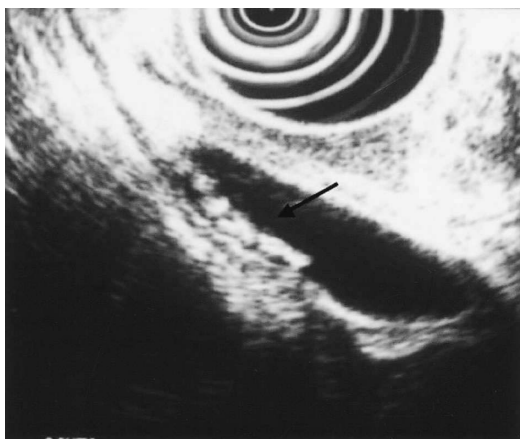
Endoscopic ultrasonography. The gallbladder was enlarged, and debris was identified. A strongly echogenic lesion consistent with a gallstone was identified. The arrowhead indicates debris.
